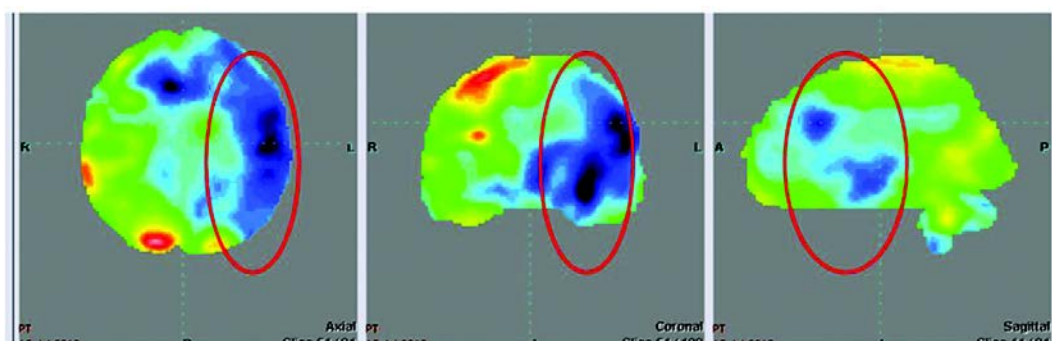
PET-CT scan before Autologous BMMNCs transplantation suggestive of hemorrhagic stroke in the region left parietal lobe with black areas suggestive of gliotic areas where as the blue regions suggestive of penumbra
